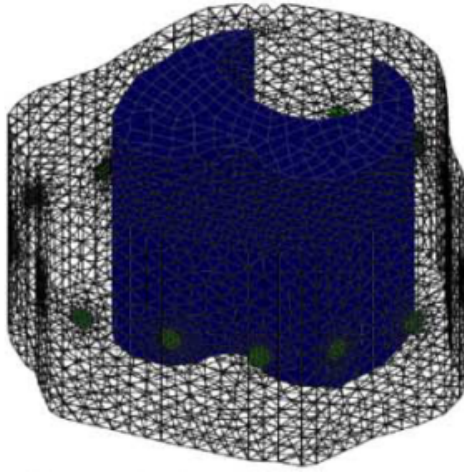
Thorax model created from a 2D outline - Based on a 2D outline of the thorax and lungs segmented from an MRI scan, this 3D head model was generated with Netgen directly in EIDORS (Grychtol et al., 2012).
